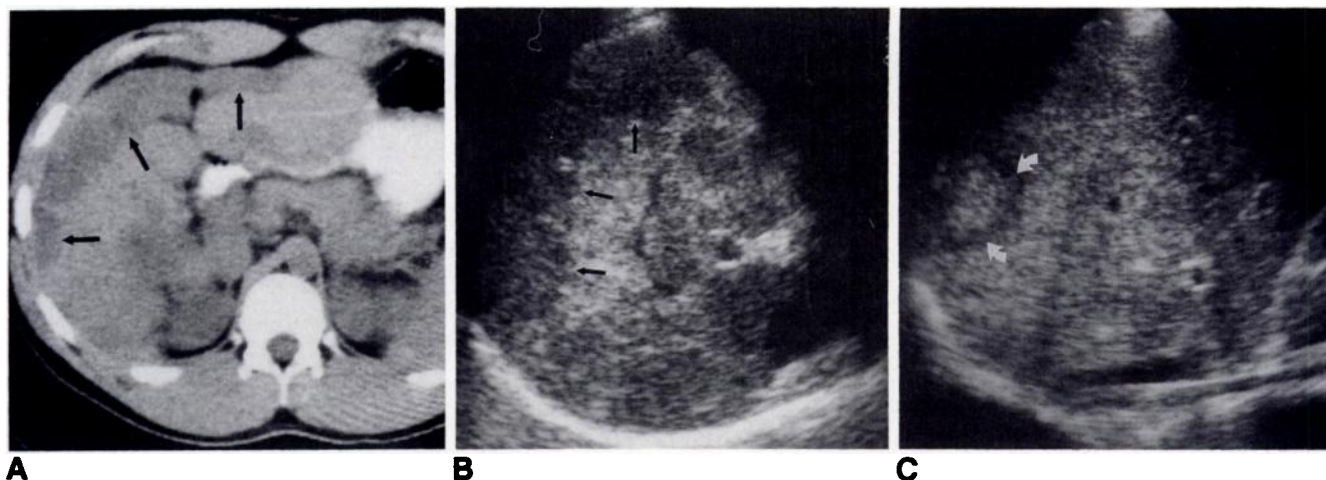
Hepatic epithelioid hemangioendothelioma with CT and sonographic correlation and different sonographic appearances in 25-year-old man.
